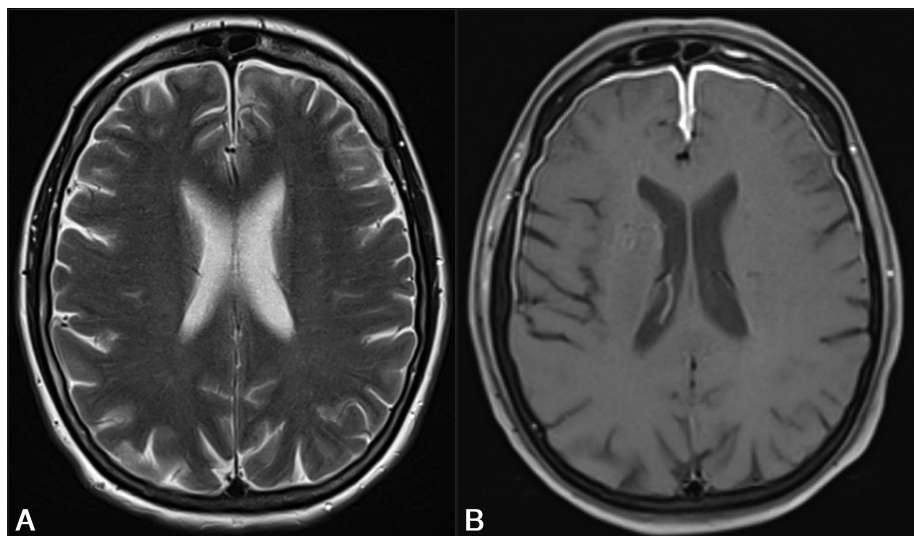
Axial T2-weighted (A) and T1-weighted image (B) of brain MRI demonstrating mild T2 hyperintensity of bilateral frontal cortex and contrast enhancement of the dura mater
